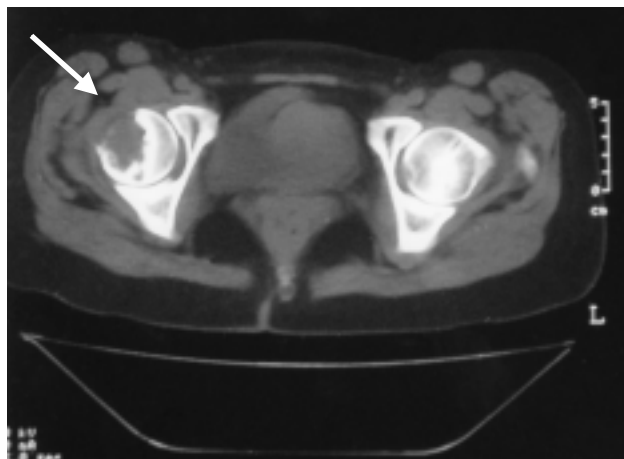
A computed tomographic scan showing a lytic lesion in the anterolateral aspect of the right femoral head with destruction of the cortex (arrow).
